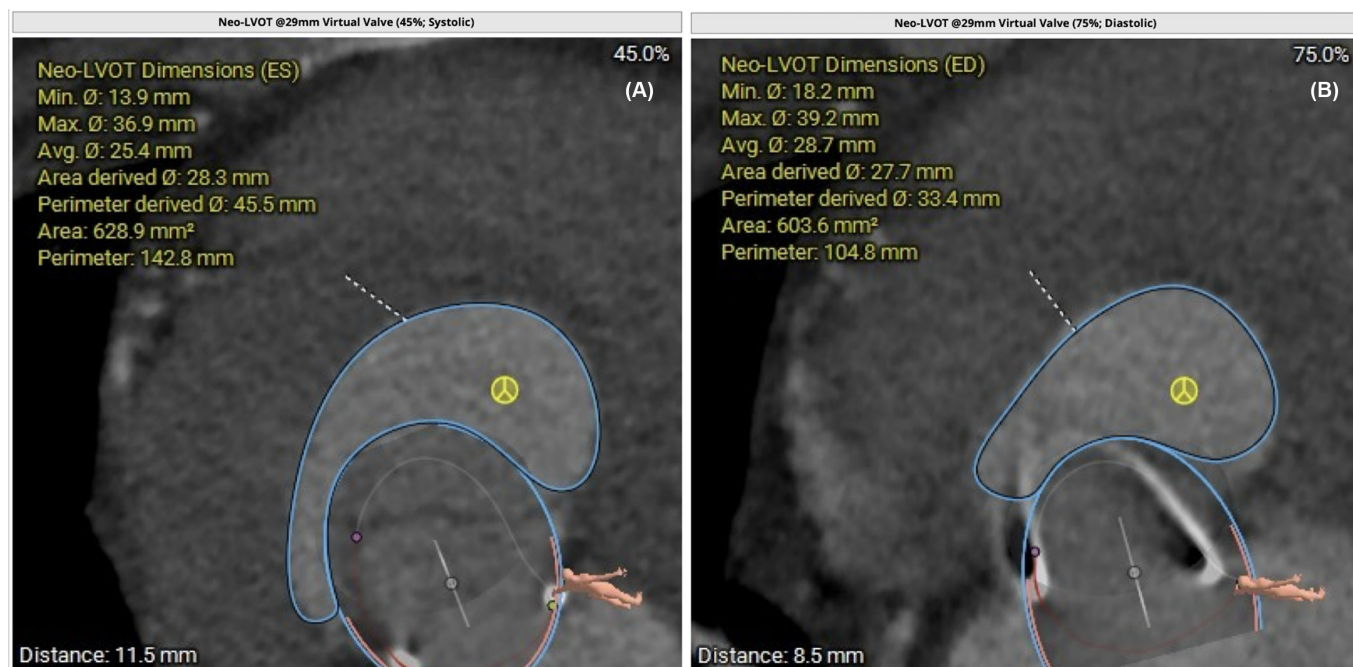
Pre-procedural computed tomography angiography evaluation showing the neo-left ventricular outflow tract (neo-LVOT) at 29 mm virtual valve with 45% systolic (A) and 75% diastolic (B) area.
